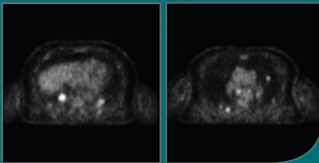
Axial CT image showing tumours in mid torso
